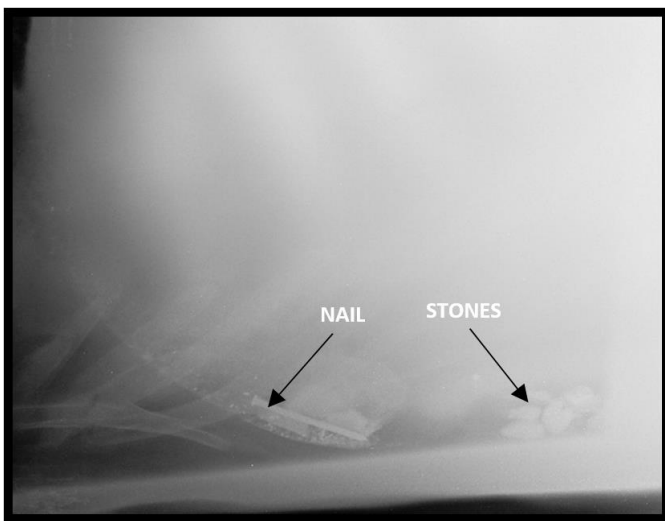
Radiograph showing nail and stones in reticulum
